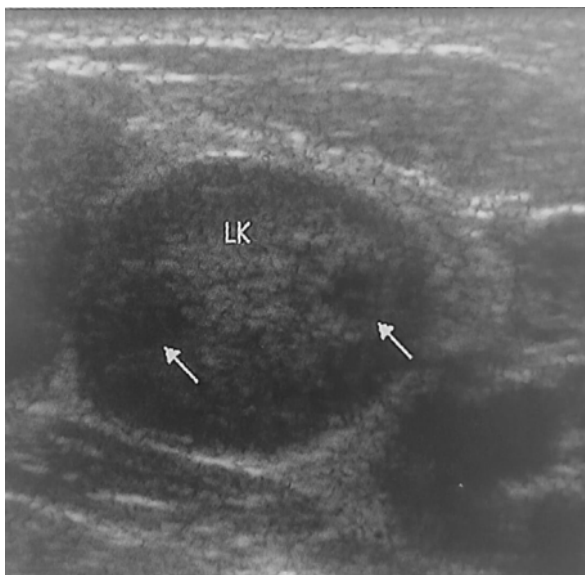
Ultrasound neck showing a well-defined heterogeneous lesion in the left cervical region.
